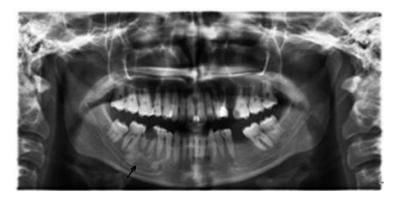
Panoramic radiograph showing an apical and interradiculer COL at right mandibular first molar
